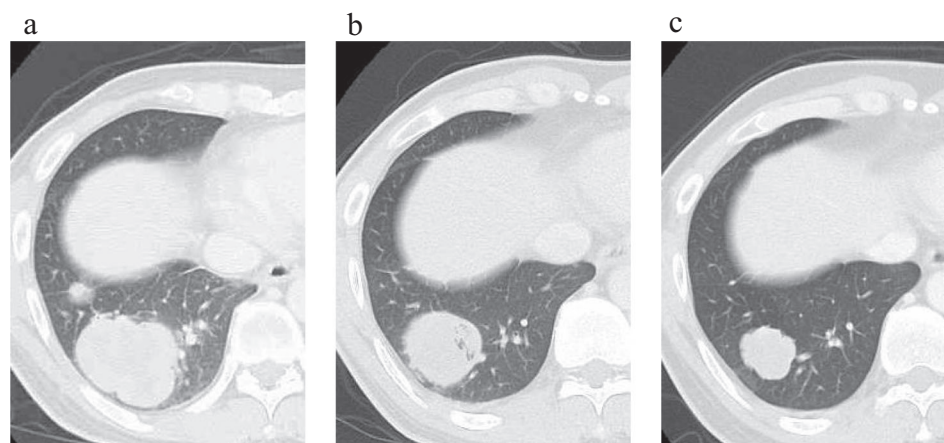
Chest computed tomography images: (a) Baseline before nivolumab treatment; (b) partial response after four doses of nivolumab; and (c) after 22 doses of nivolumab.
